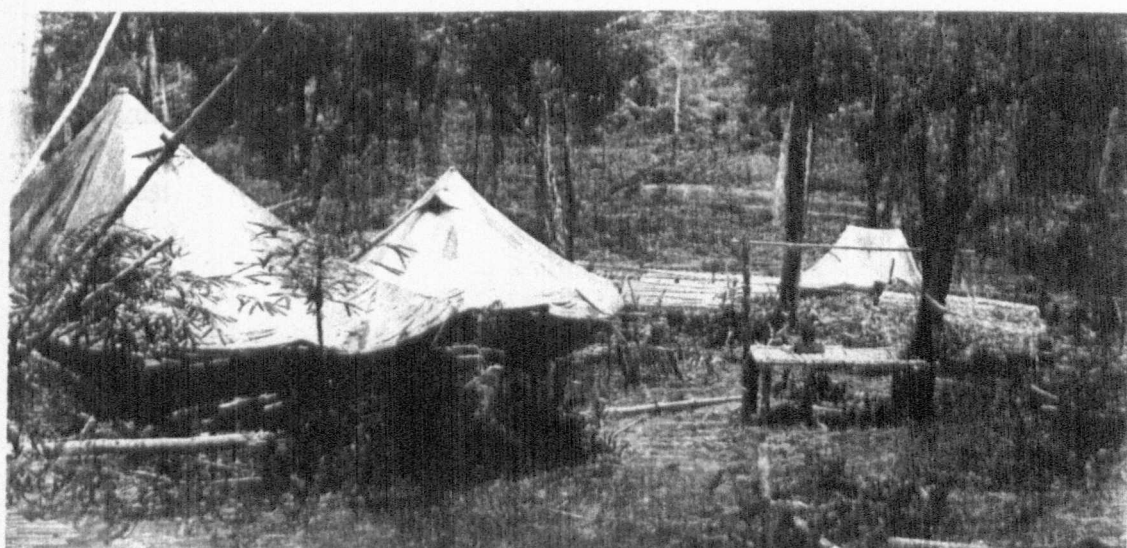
“Cholera Hill” at Sonkrai No 1 Camp – a makeshift tented area to the north of the main camp. The photograph was secretly taken by George Aspinall, an Australian POW, using X-ray film brought up from Singapore.⁷⁰
